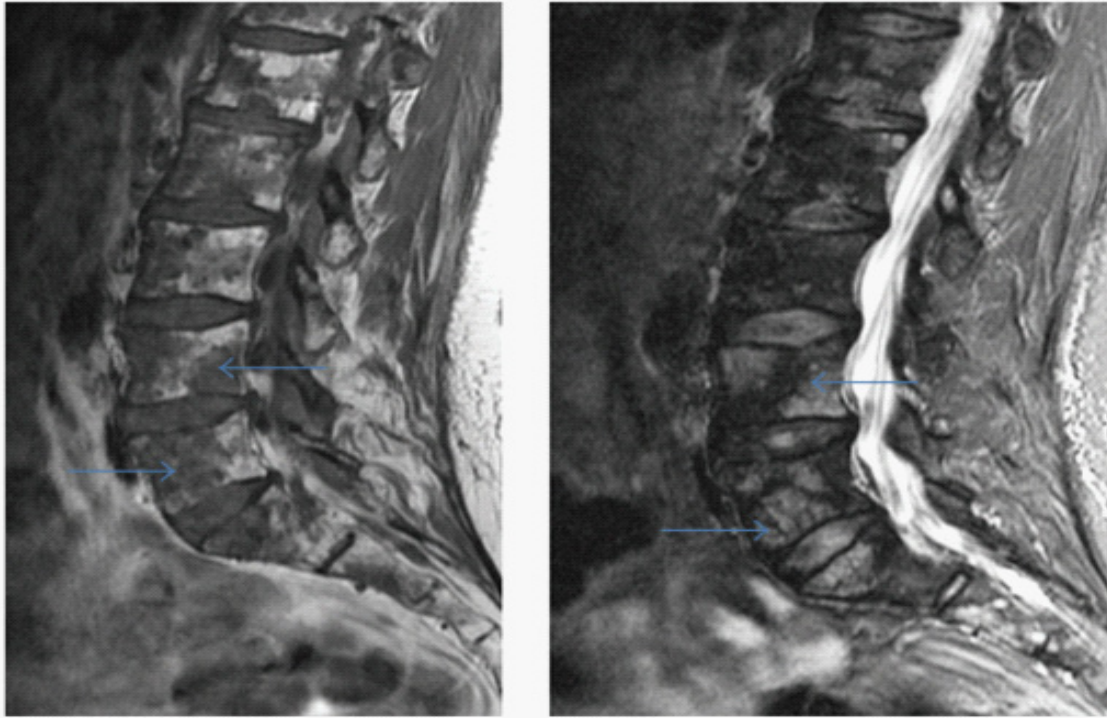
MRI sagittal T1-weighted sequence lumbar spine: diffuse permeative low signal myelomatous marrow lesions throughout the lumbar spine (arrow). (b) MRI sagittal T2-weighted STIR sequence (same patient): diffuse high signal myelomatous marrow lesions throughout the lumbar spine (arrow)
